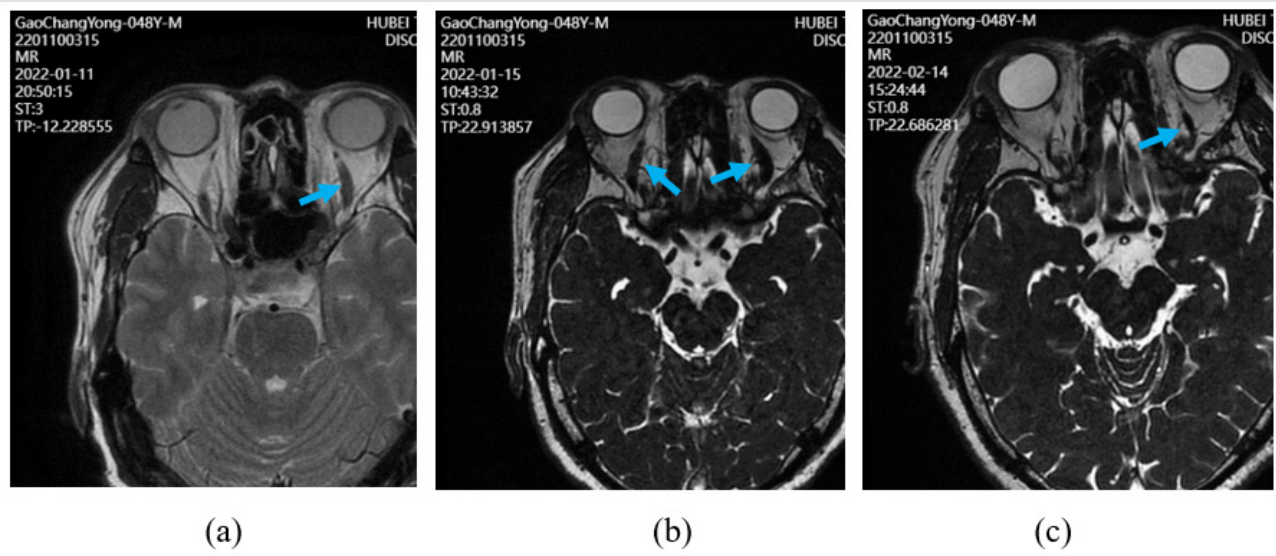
MRI of superior ophthalmic vein and jugular vein.
